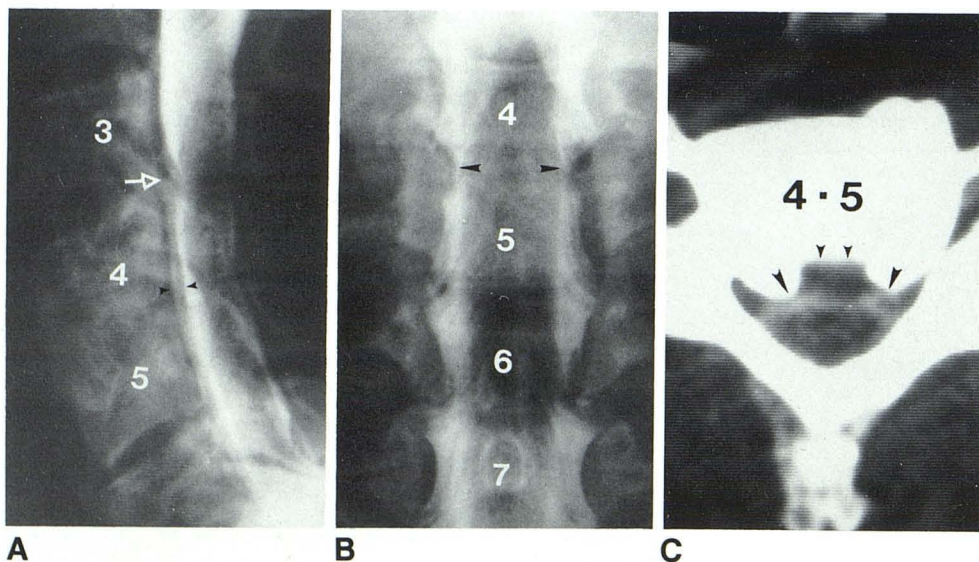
49-year-old man after C4–C5 anterior cervical discectomy and fusion with recurrent cervical myeloradiculopathy. A, Lateral myelogram. C3–C4 defect (arrow) and double density at C4–C5 (arrowheads). B, Posteroanterior view. Bilateral C4–C5 root sleeve defects (arrowheads). C, CT myelogram. Surgical defect (small arrowheads). Because of inadequate curettage of lateral recesses, residual spurs (large arrowheads) result in continued stenosis, cord compression, and persistent symptoms.
